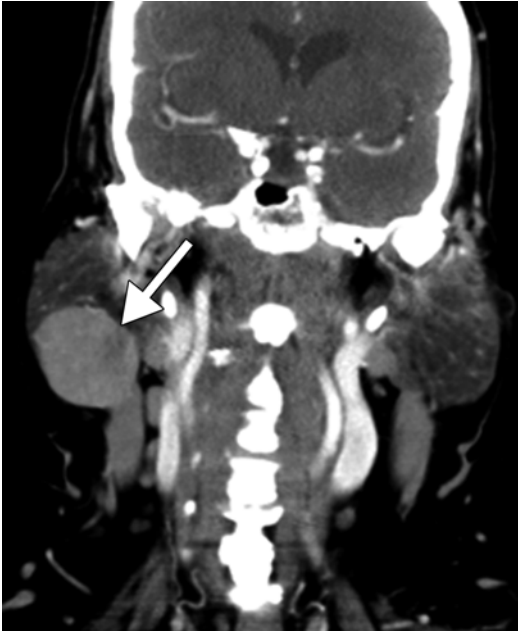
Warthin tumor. This smoker with COPD presented with growing right-sided neck mass. The coronal post-contrast CT image shows a well-defined hyperattenuating mass within the right parotid tail (*arrow*)
